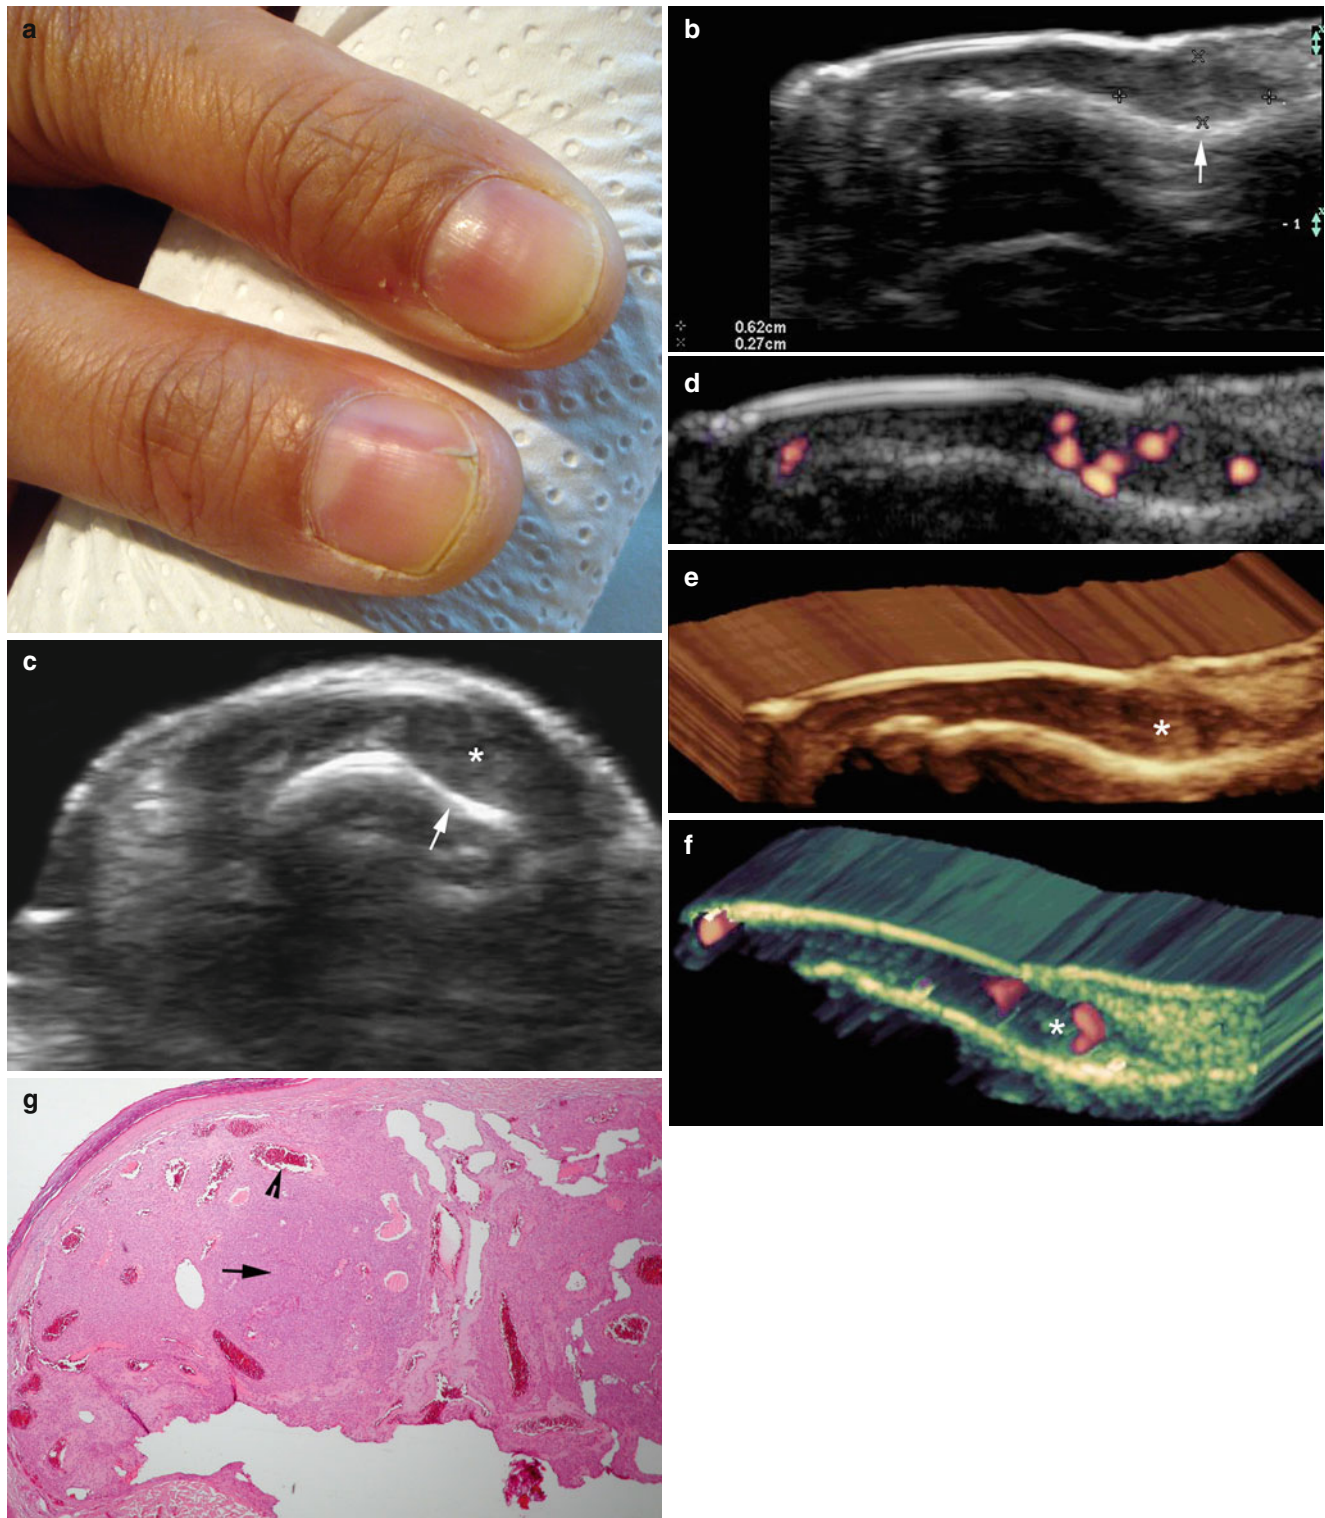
(a–g) Glomus tumor. (a) Clinical image shows a longitudinal defect in the distal nail plate of the right thumb. (b, c) Grey scale ultrasound images (b longitudinal view; c transverse view, right thumb) show a 6.2 mm (long) \times 2.7 mm (depth), well defined, hypoechoic nodule (*, between markers) in the radial aspect of the proximal nail bed (same axis of the visible lesion). Scalloping of the bony margin (arrow) is also detected. (d) Power Doppler ultrasound image (longitudinal
